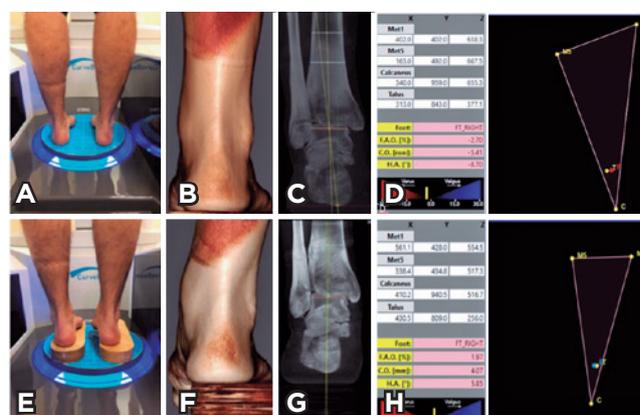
A and B. Protocol for weight-bearing computed tomography (WBCT) scanning in an upright position. C. Hindfoot angle measured on the inferior point of the calcaneus (HA_{IC}) in an upright weight-bearing position showing varus. D. Foot and ankle offset (FAO) in an upright weight-bearing position. E and F. WBCT scanning during the Coleman block test. G. HA_{IC} during the Coleman block test showing hindfoot valgus. H. FAO during the Coleman block test
